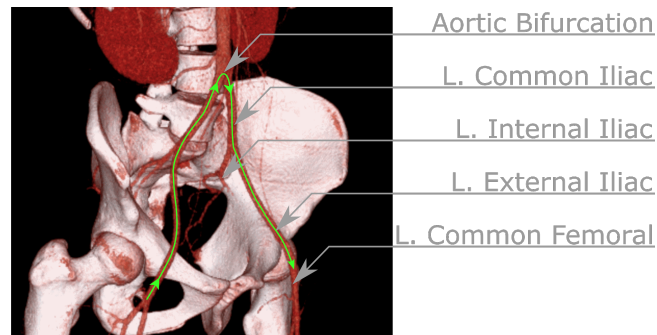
Volume rendered CT showing a contralateral retrograde access from the right common femoral artery to the left via the aortic bifurcation.
